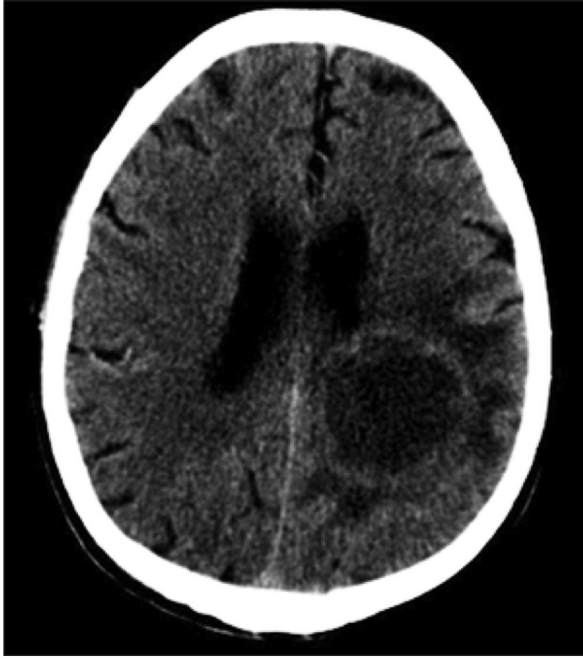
Brain CT shows solitary 45 mm lesion left parietal region of the brain.
